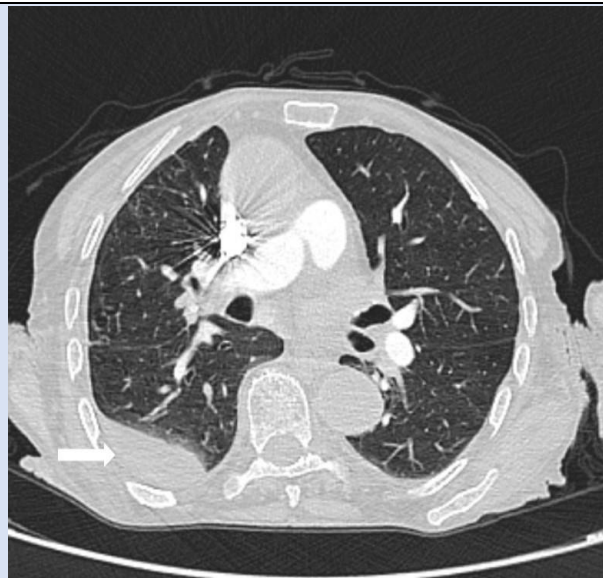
Thoracic CT showing loculated pleural effusion in the right hemithorax and mediastinal lymphadenopathy.
